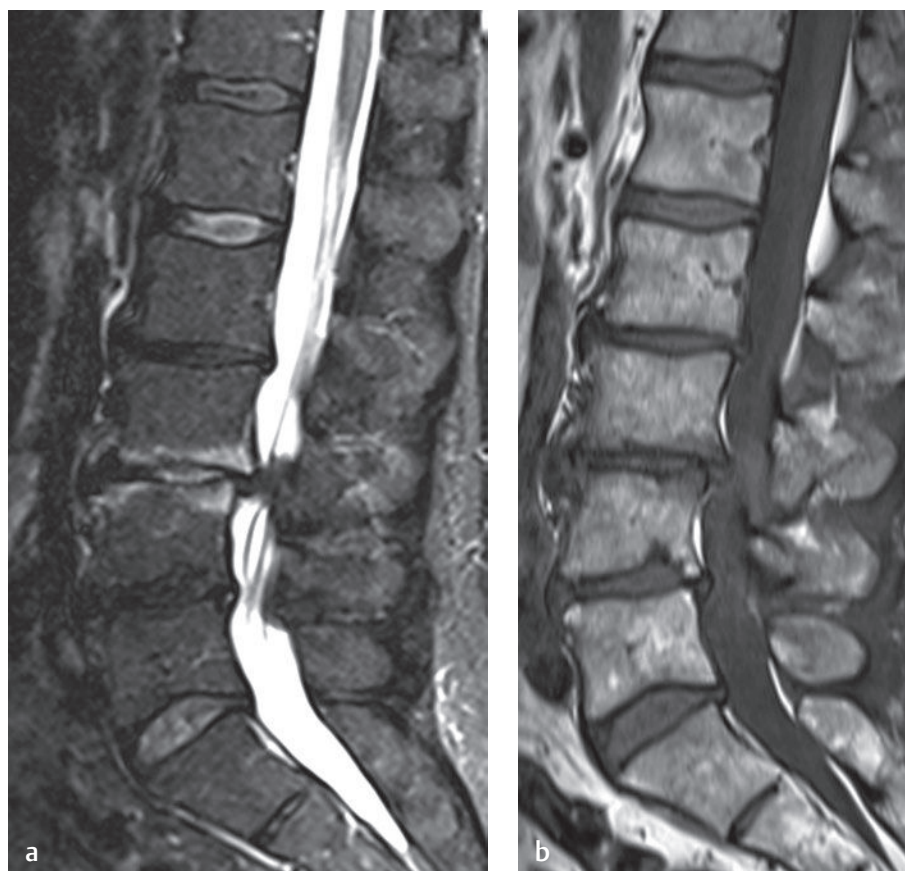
Modic type-I degenerative end-plate changes. (a) A sagittal STIR image shows bright signal compatible with edema within the inferior L3 and superior L4 end plates. (b) The corresponding sagittal T1-weighted image shows subtle low signal in the same areas.
